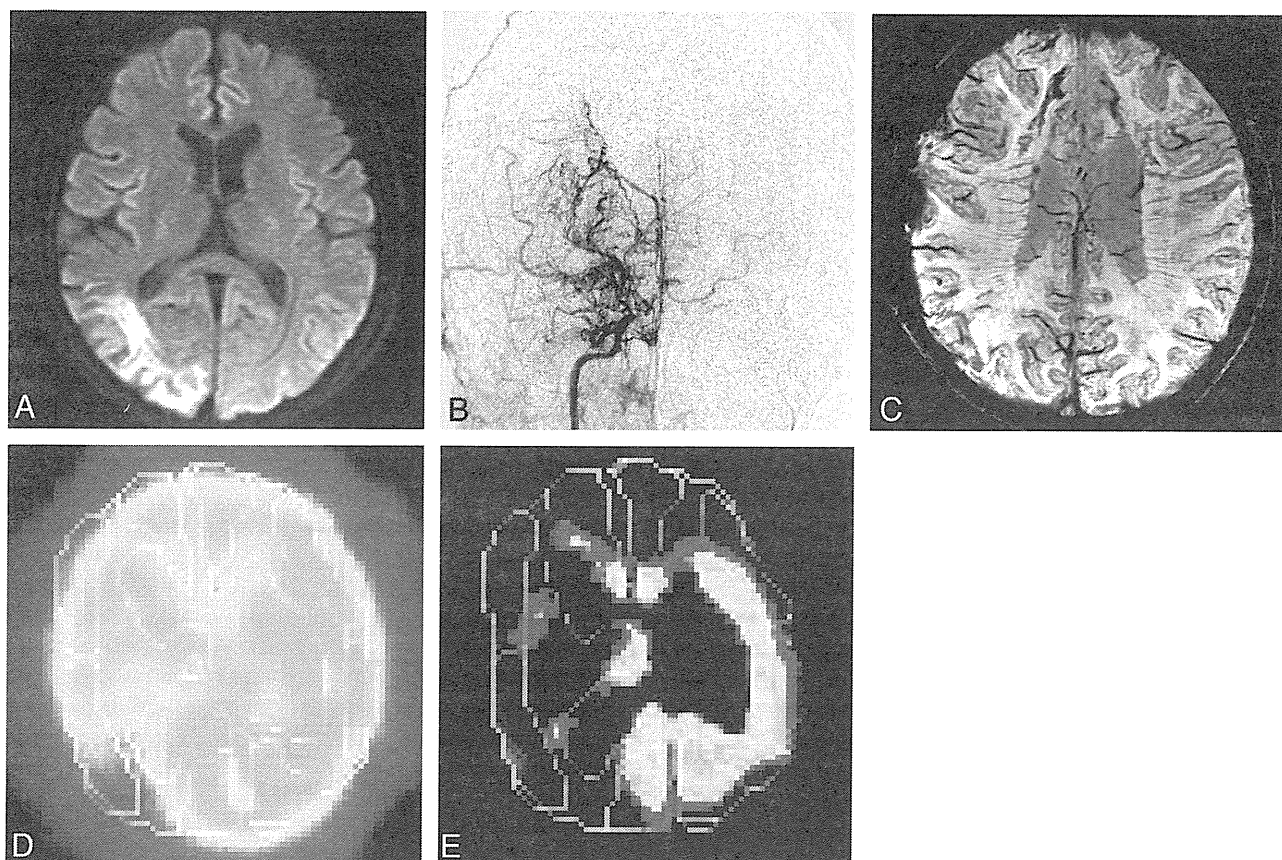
A, 37-year-old man showing infarction in the right occipital lobe. B, Intra-arterial angiography showing Suzuki stage 3 MMD. Brush signs can be seen in the deep white matter on SWI (C) with low CBF (D) and CVR (E) on SPECT.
